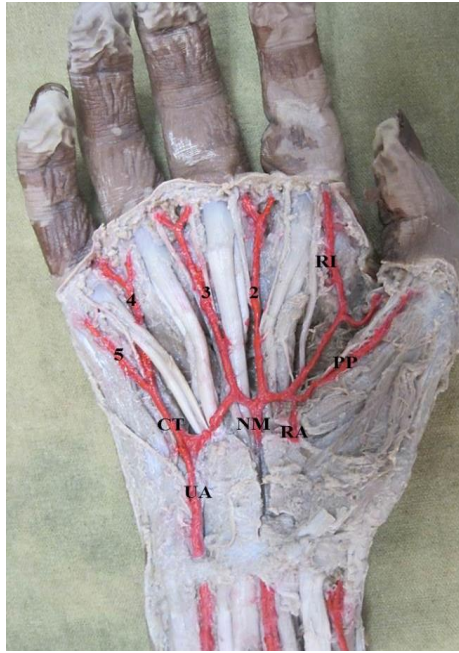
Right hand showing a Complete SVA (radio-medio-ulnar communication). UA – Superficial branch of ulnar artery; RA – Superficial branch of radial artery; NM – Arteria Nervi Mediana; RI – Arteria radialisindicis; PP – Arteria princepspollicis; 2, 3, 4 – 2nd, 3rd and 4th common digital arteries; 5 – Proper digital artery; CT – common trunk for 4th common digital artery and proper digital artery for the little finger.
